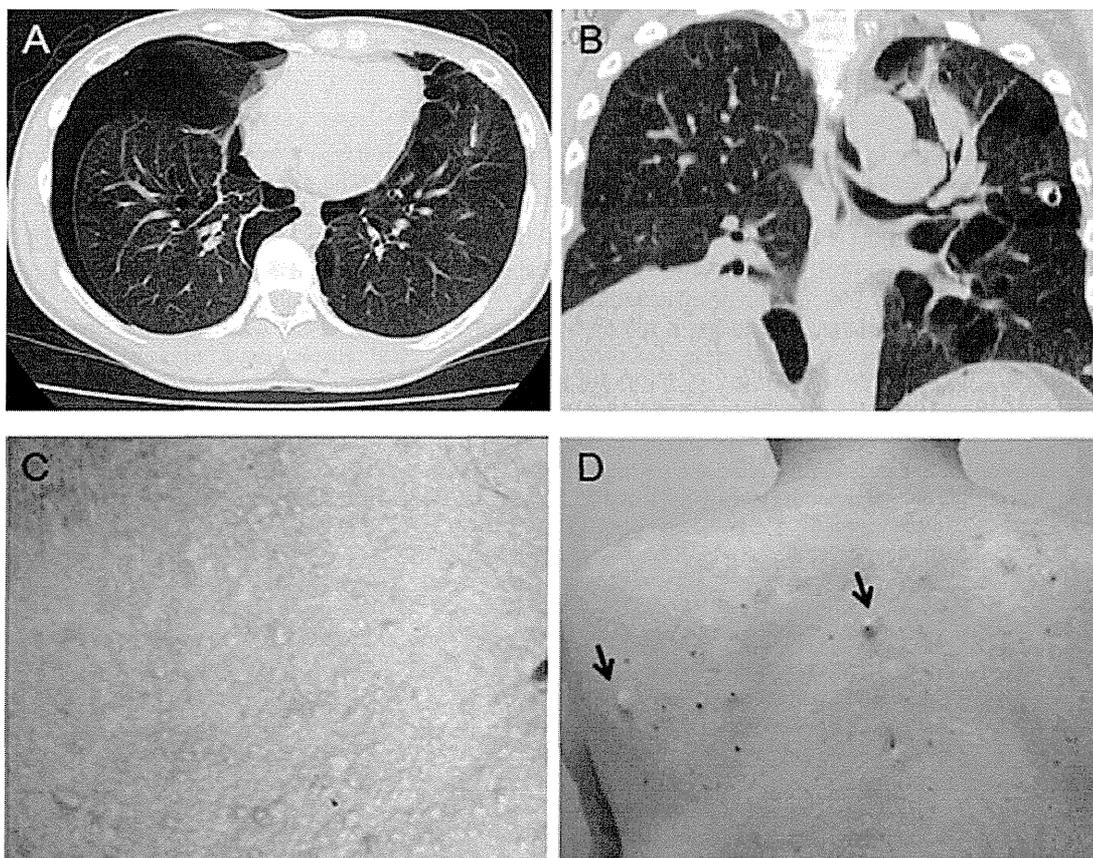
Thoracic CT scans and skin tumours of patients with Birt-Hogg-Dubé syndrome. (A) A 33-year-old woman who had a pneumothorax six times showing cysts localised in the perimedial subpleura. (B) A 53-year-old woman who had a pneumothorax twice showing most of the cysts in contact with the interlobular septum. (C) A 69-year-old woman with renal cell carcinoma who had multiple skin papules on the neck. (D) A 76-year-old man with a few flat-topped fibrous papules on the back (arrows).
